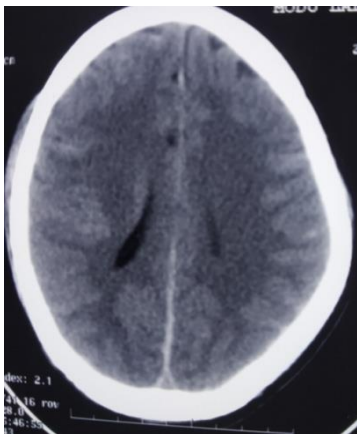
(B): (CT scan after 24 hrs shows rapid resolution of SDH.
